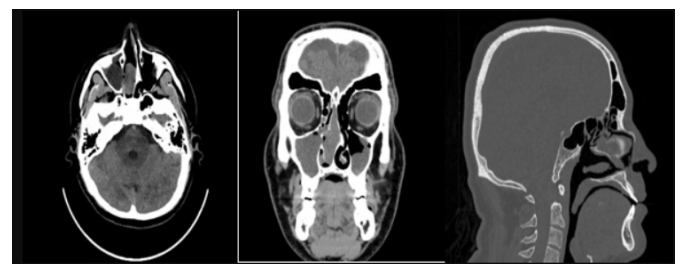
Paranasal sinus computed tomography of the patient
